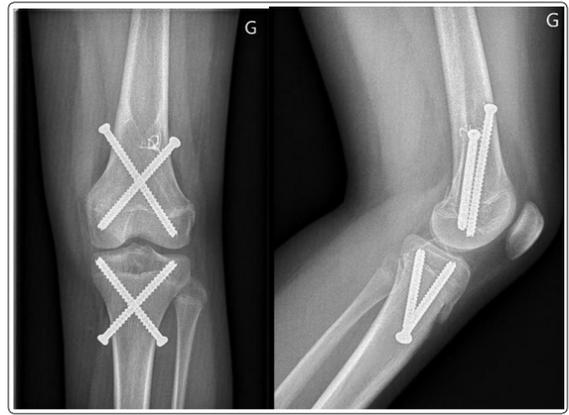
Left knee X-ray face and profile (August 2020): Last surgery after 6 months, when the varus was corrected, epiphysiodesis of the distal femur and proximal tibia was realized
